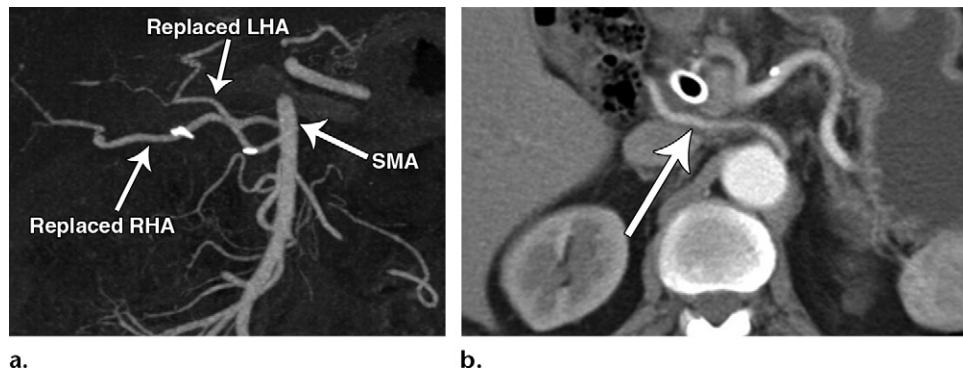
Peripancreatic arterial anatomic variants in two patients. A replaced right hepatic artery is one of the most common anatomic variants in the peripancreatic arterial structures. (a) Maximum intensity projection CT image of a 67-year-old man shows a replaced right hepatic artery (RHA) and a replaced left hepatic artery (LHA) originating from the SMA. (b) Axial CT image of a 66-year-old woman shows a replaced right hepatic artery (arrow) arising from the aorta.
